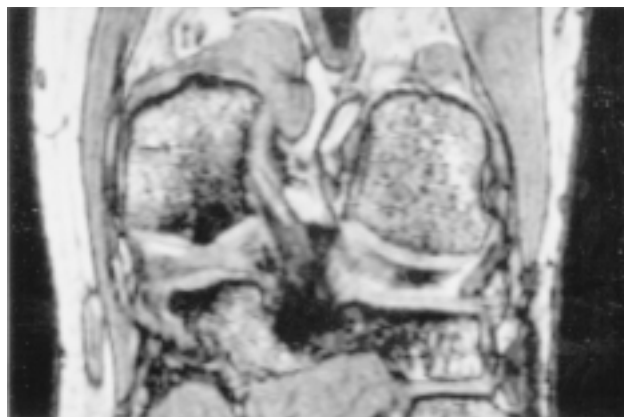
Gradient echo MRI image. Small micrometal artefacts in the meniscus, showing the previous site of suture.
